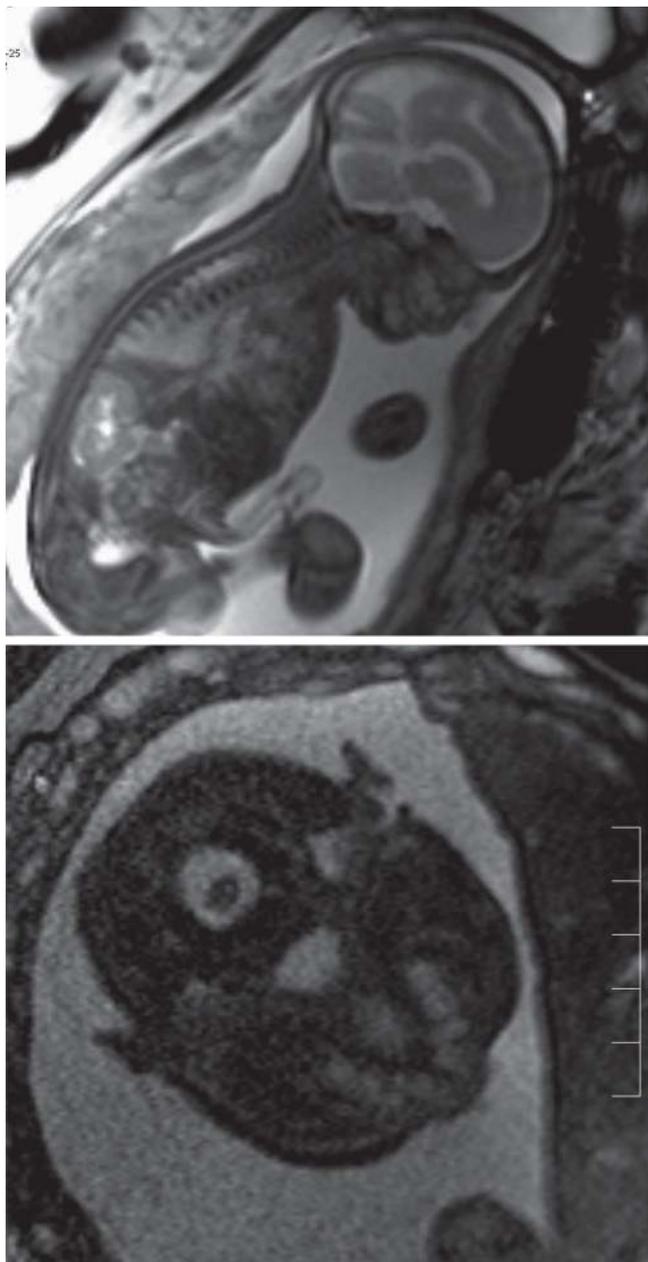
Tooth germs of subject M2 visualized by fetal MRI.
